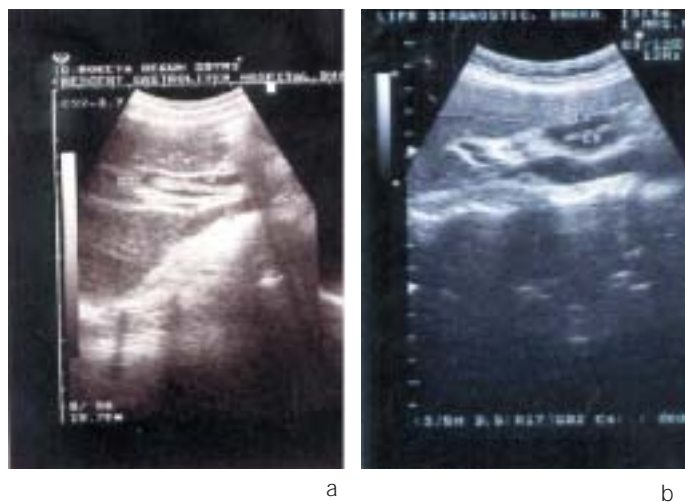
Ultrasonogram showing *Ascaris* inside the common bile duct (3a) and inside the gall bladder (3b).
